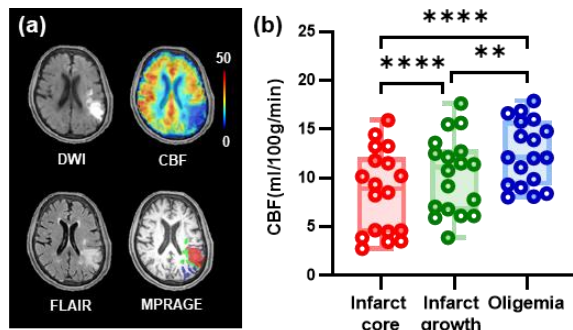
(a) Definition of regions of interest. Red: infarct core (region in both the acute DWI lesion and final infarct area), green: infarct growth (region in the final infarct but not in the acute DWI lesion area), and blue: oligemia (region in the perfusion deficit area but not in the DWI lesion nor the final infarct area). (b) Comparisons of mean CBF values among different regions within hypoperfused tissue.
